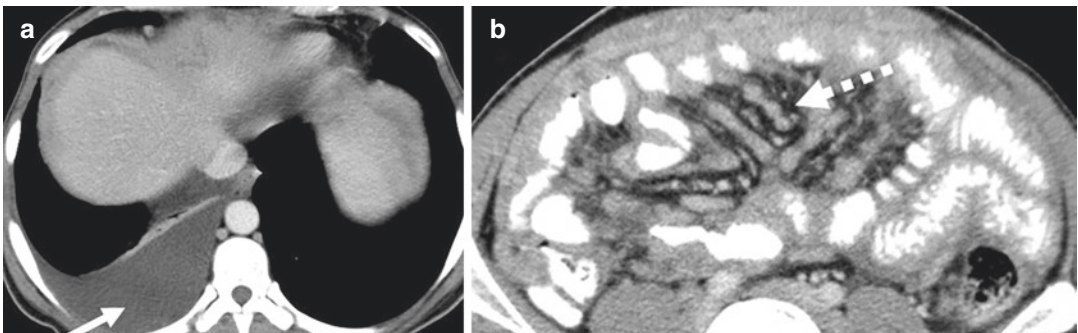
Peritoneal tuberculosis in a 35-year-old man with anorexia and weight loss for 6 months. (a and b) Axial contrast-enhanced CT images show a right pleural effusion (white arrow). There is mesenteric nodularity and thickening (dashed white arrow) and diffuse small bowel wall thickening due to serosal involvement
